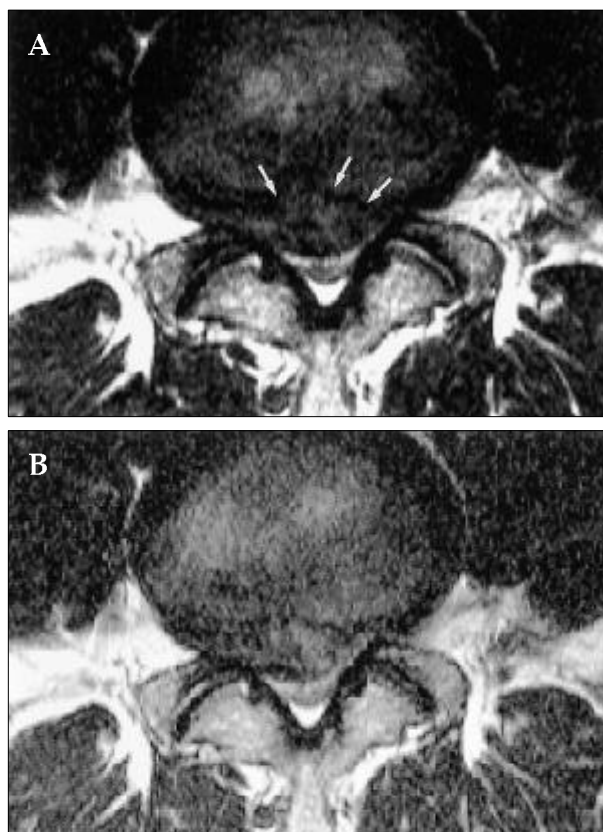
Morphologic changes in a large central extruded disc. Axial turbo T2-weighted images (3800/128) in a 27-year-old man with right-side sciatica. A, Large central extruded disc was observed in the initial study (arrows). B, A follow-up study showed no change of size in the herniated disc 4 months later. However, the patient showed no pain or limitation, except for a mild low back pain during work.
